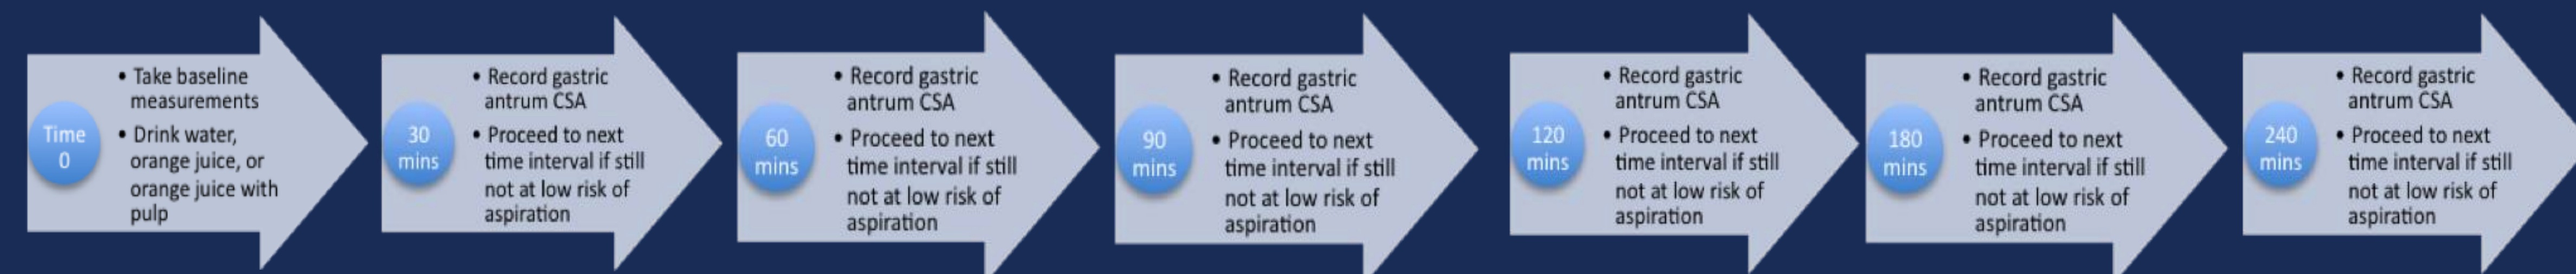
Timeline of gastric ultrasound measurements
